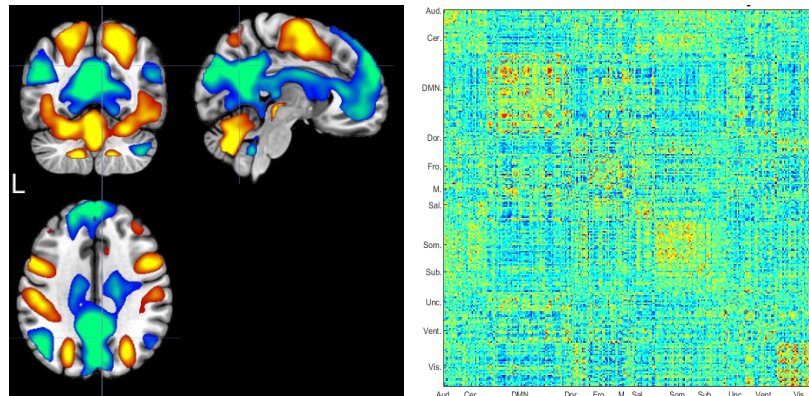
Examples of results computed from MRI data. BOLD activation analysis (left) and connectivity analysis in the form of connectivity matrix (right). Own data.
